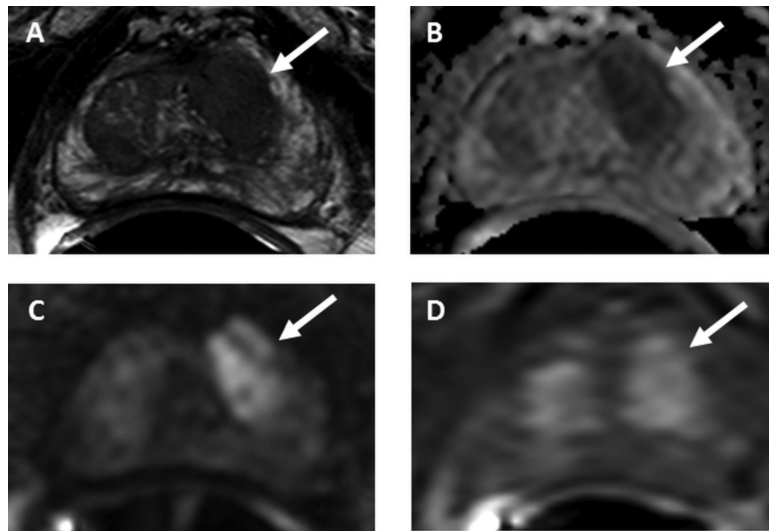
A 71 year man with serum PSA of 5.47ng/ml was found to have Gleason score 3+3 cancer (5%) on random biopsy. Due to rising PSA levels, he underwent MRI scan prior to enrollment in active surveillance. (A). An axial T2-weighted MRI scan shows a PI-RADS 5 lesion in the left mid-anterior transition zone (arrow). (B-D) The lesion is positive on the apparent diffusion coefficient map (B), diffusion-weighted MRI ($b=2000\text{mm/s}^2$) (C), and dynamic contrast-enhanced MRI (D; arrows). A TRUS/MRI fusion-guided candidate after multiparametric MRI and a TRUS/MRI fusion-guided biopsy approach. Abbreviations: PI-RADS, Prostate Imaging Reporting and Data System; PSA, prostate-specific antigen; TRUS, transrectal ultrasonography.
